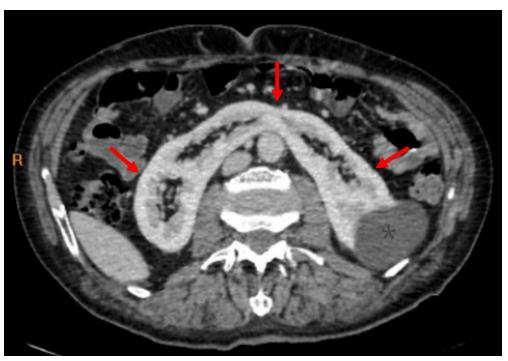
Horseshoe kidney (arrows) as seen at CT. Renal cyst (asterisk).
